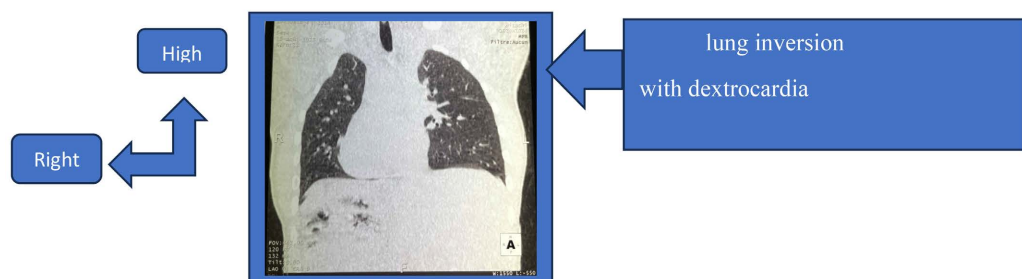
Frontal thoracic CT section.
